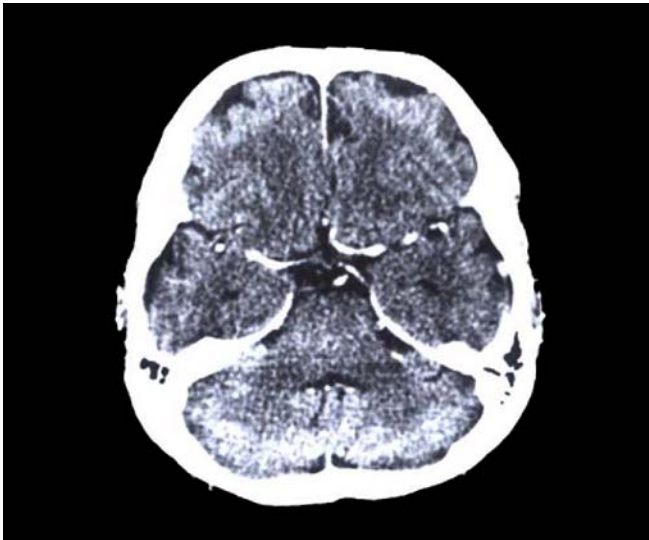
Multiple foci of decreased density on CT scan in the white matter
